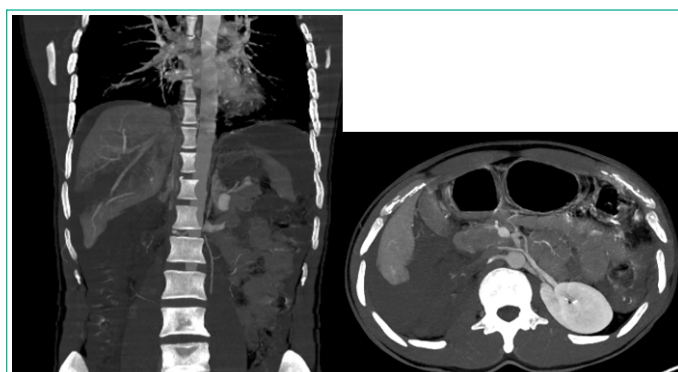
Coronal CT scan showing the right renal artery dissection (red arrow) with a renal devascularization (blue arrow) and the hepatic fracture (yellow arrow).
